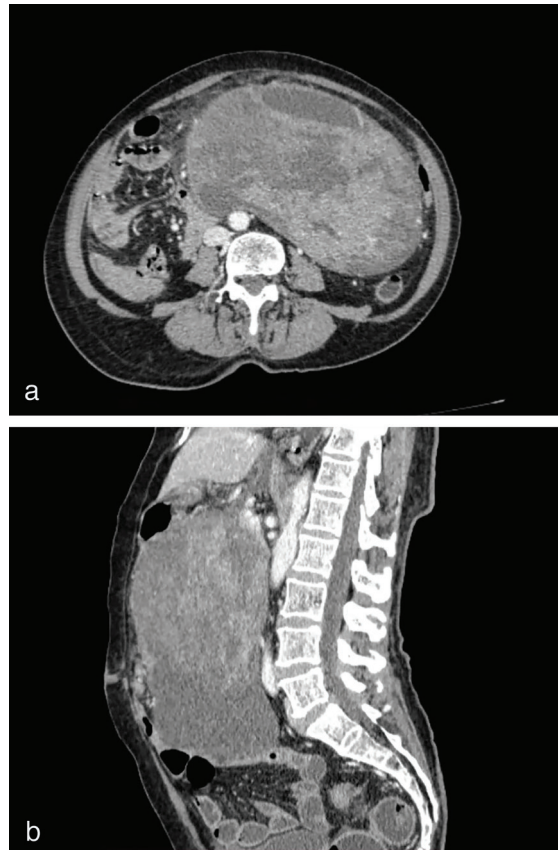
(a, b) CT features of a large heterogeneously enhancing and hypervascularised intraperitoneal mass that appears to arise from the stomach (greater curvature) with a cystic component.
